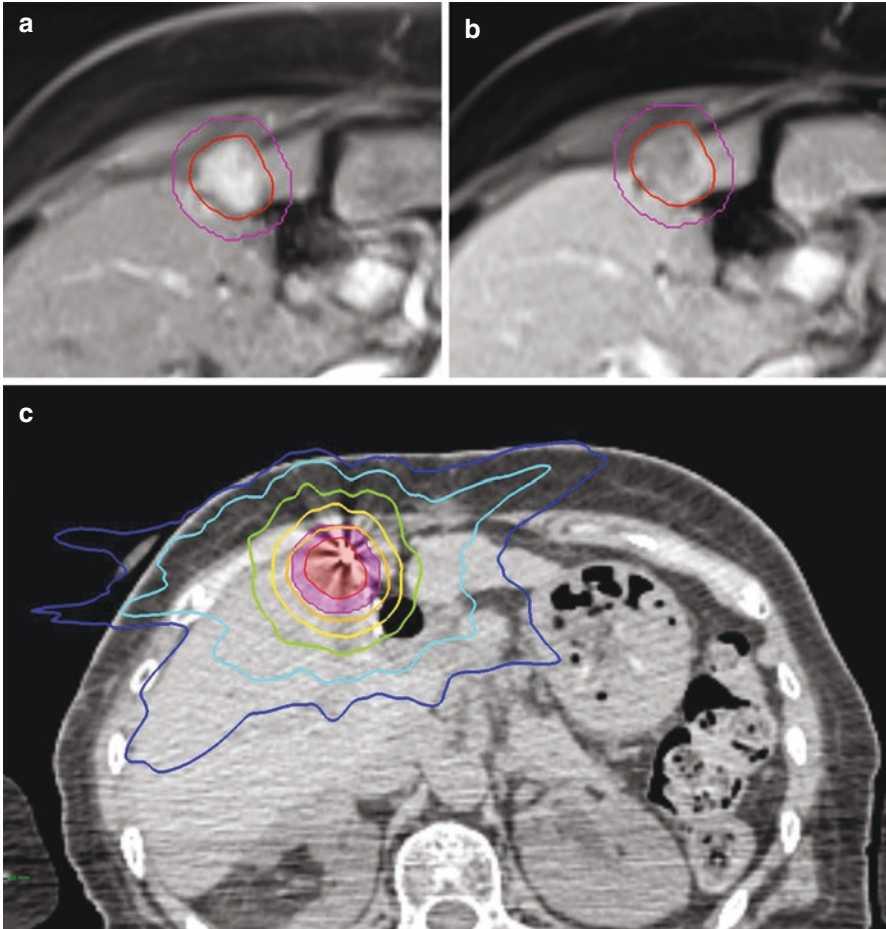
A patient with HCC treated with SBRT using CyberKnife, prescribed 45 Gy in three fractions. Two different gadolinium-enhanced MRI sequences (a and b) were selected based on good visualization of tumor and fused to treatment planning CT for tumor delineation, with the GTV delineated in red and PTV in purple generated using 5 mm radial expansions. (c) Doses shown as calculated on planning CT with the GTV shaded red and PTV shaded purple. Orange, 45 Gy; yellow, 30 Gy; green, 20 Gy; light blue, 10 Gy; dark blue, 5 Gy
